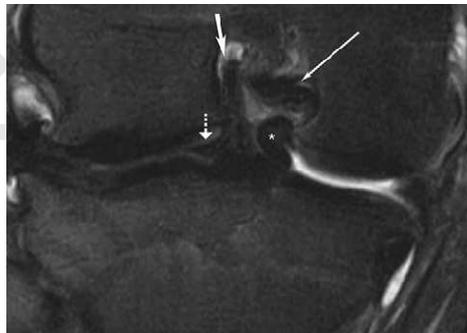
FSE T2-weighted fat-saturated coronal image demonstrating bucket-handle tears of both menisci, with fragments from both meniscal bodies flipped into the intercondylar notch. The fragment of the medial meniscus (asterisk) is inferior to the PCL (thin arrow) and the fragment of the body of the lateral meniscus (dotted arrow) is adjacent to the ACL (thick arrow), producing the “quadruple cruciate sign.”⁽²⁵⁾
